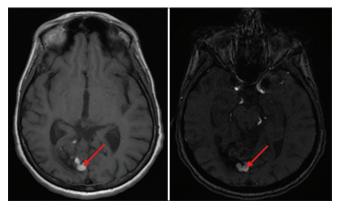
Axial sections of T1-weighted brain MRI with and without contrast showing the embolized right occipital intracranial arteriovenous malformation (red arrows) with the embolization material appearing as hyperintense.
